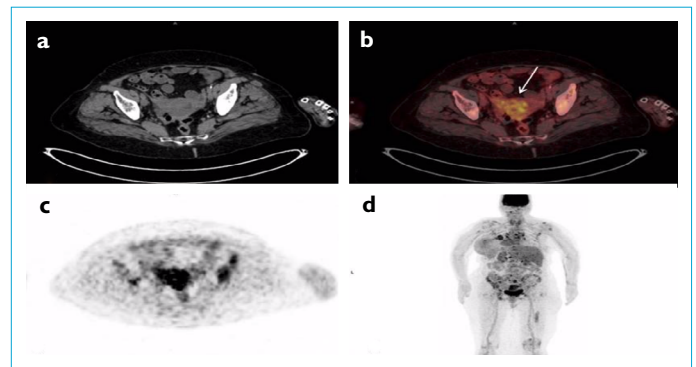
(a-d). Transaxial CT (a), fused (b), PET (c) and MIP (d) images of the 18F-FDG PET/CT scan. Uterine metastases were depicted on 18F-FDG PET/CT imaging (arrow, b).
